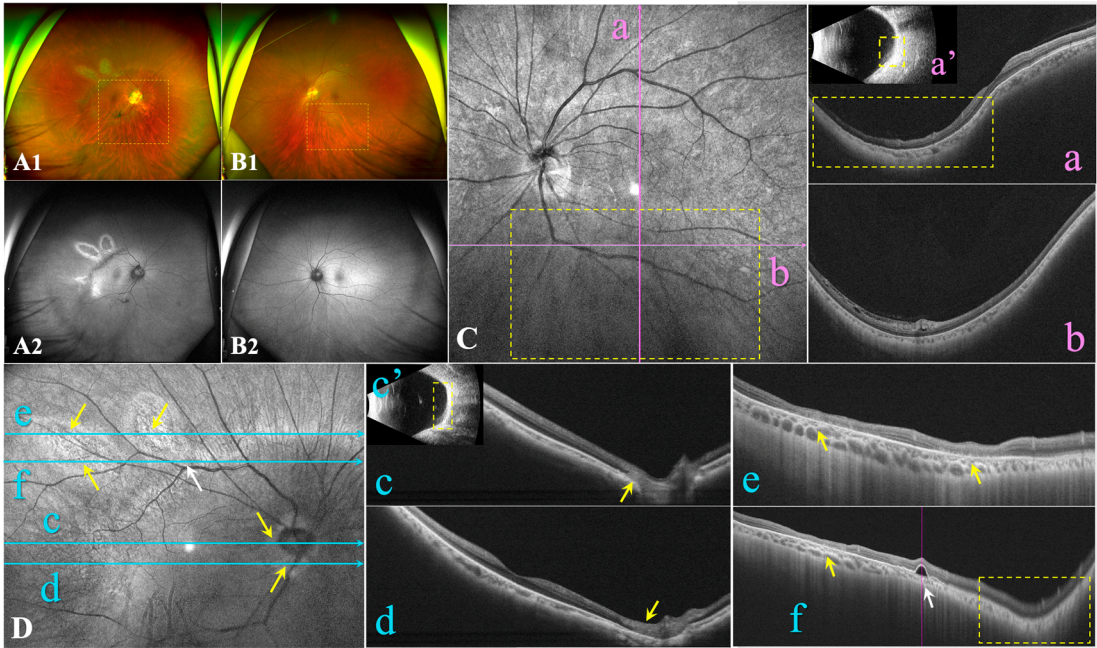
Ocular characteristics of F-I2. A-B: Ultra-widefield fundus images include both colour fundus and autofluorescent images. C: Optical coherence tomography (OCT) B-scan (Ca, b) and B-ultrasound (Ca') of the left eye reveal inferior posterior staphyloma (PS) with retinoschisis. D: OCT B-scan (Dc, f) and B-ultrasound (Dc') of the right eye reveal a wide macular PS. OCT B-scan of the right eye reveals focal circular areas of retinal atrophy and choriocapillaris atrophy located in the region adjacent to the disc (Dc, d) and the supertemporal vascular arcade (De, f), with pigment epithelial detachment (PED) close to the retinal atrophy lesion (Df). Yellow arrows refer to focal circular areas of retinal atrophy and choriocapillaris atrophy. Yellow dotted squares indicate the site of PS. White arrows indicate PED.
